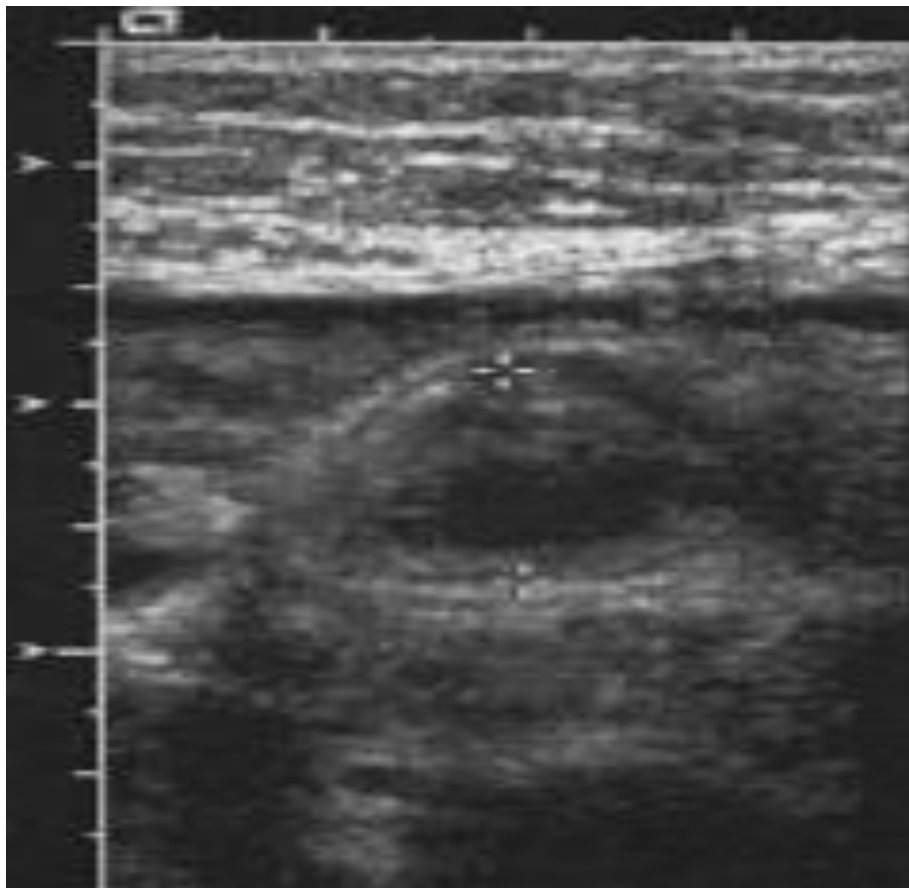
Ultrasonogram showing acute appendicitis
